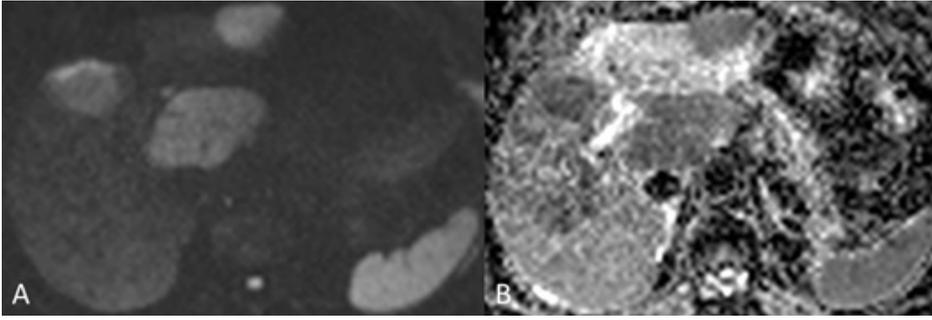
MRI (A, DWI (B=800); B, ADC map). Note an additional lesion on the segment IV. All lesions demonstrate restricted diffusion with low ADC values.
